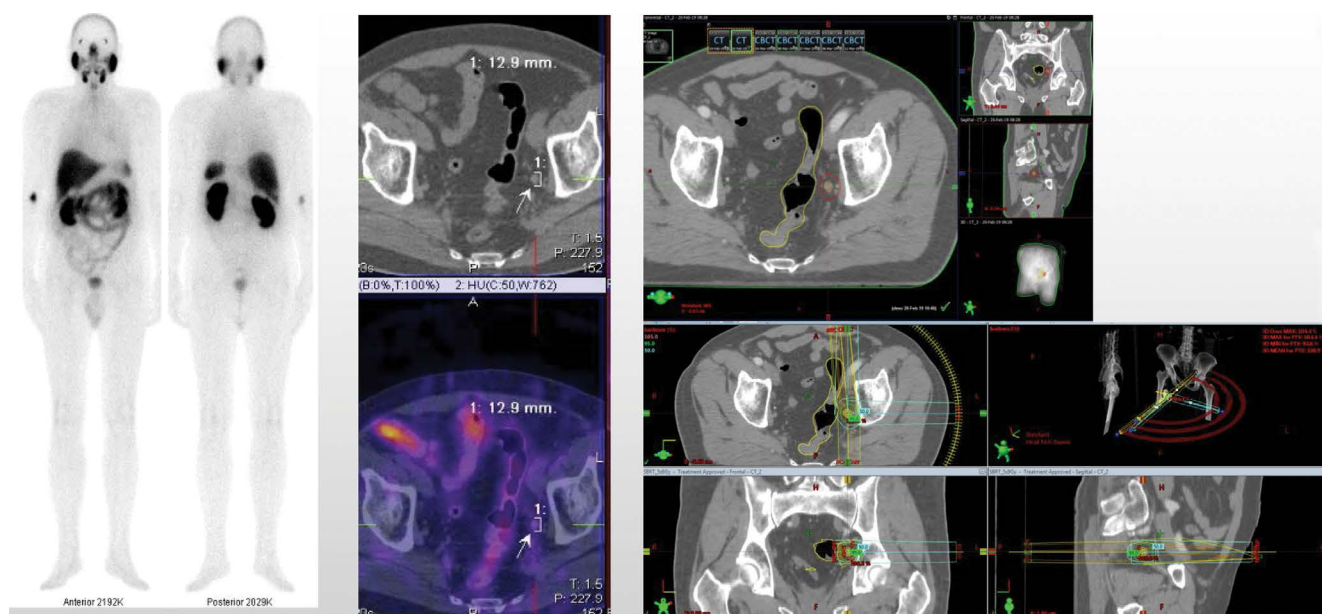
M/75yr with prostate cancer, pT2cpN0M0, Gl = 7 (4 + 3)_E. Radical prostatectomy/2016/ PSA = 0.36 ng/mL (02.2019) Whole-body scan and target [^{99m}Tc]Tc-PSMA-T4 SPECT-CT imaging showed enlarged single iliac lymph node on the left with intensive tracer uptake. Gross tumour volume (GTV) and Clinical Tumour Volume (CTV) delineation based on the [^{99m}Tc]Tc-PSMA-T4 imaging results in radiotherapy planning. Radiation dose distribution in the region of the single enlarged iliac lymph node on the left in the same patient. The PSA value decreased to 0.05 ng/mL (M.10.2019) after radiotherapy
